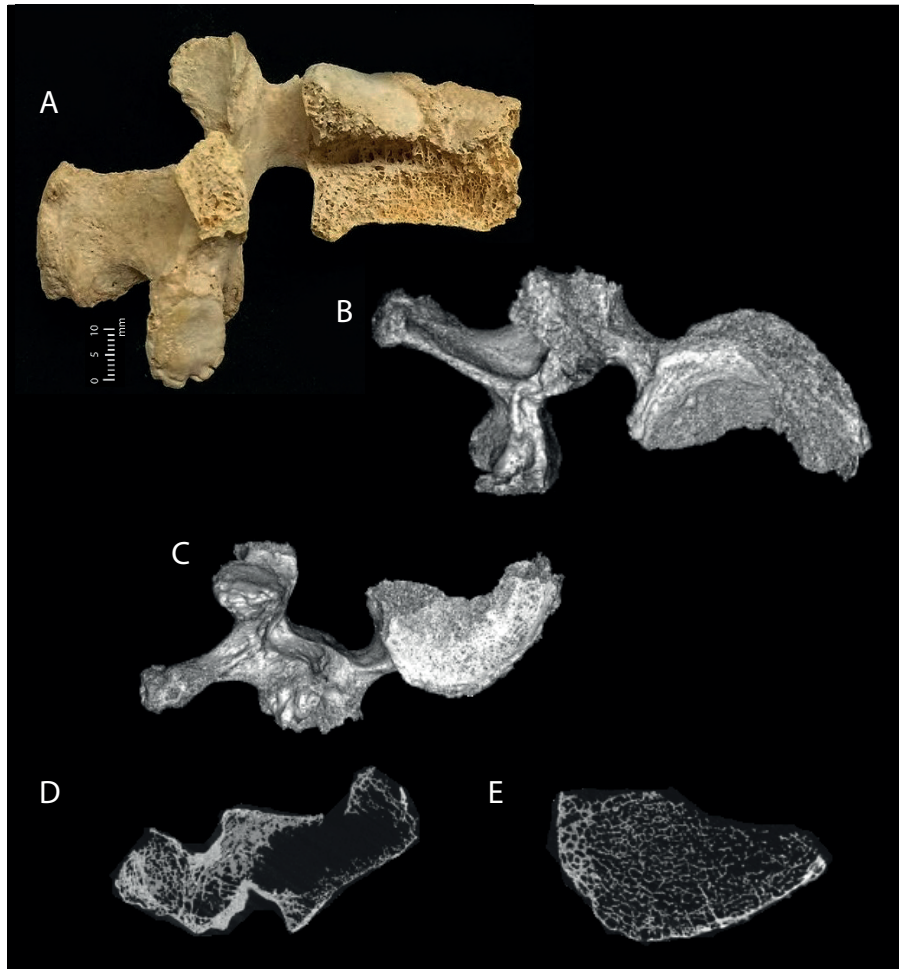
A selection of photographic and radiological images of a fragment of adult possible first lumbar vertebra (FB0027) from Context (1026) of the Circle sample, exhibiting a central compression fracture: a) right lateral view; b) 3D render superior view; c) 3D render inferior view; d) sagittal cross-section from CT data detailing depth of central depression; e) transverse cross-section detailing osteopenia indicative of osteoporosis. Scale bar: 1 cm (photograph only). (Photos Ronika K. Power; radiological images captured by L. Buck, Cambridge Biotomography Centre; processed by J. Magnussen & M. Pardey, Macquarie Medical Imaging).
